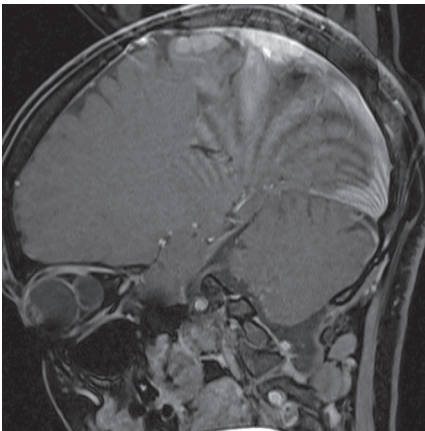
(A, B) Preoperative sagittal MRI scans of the patient.
